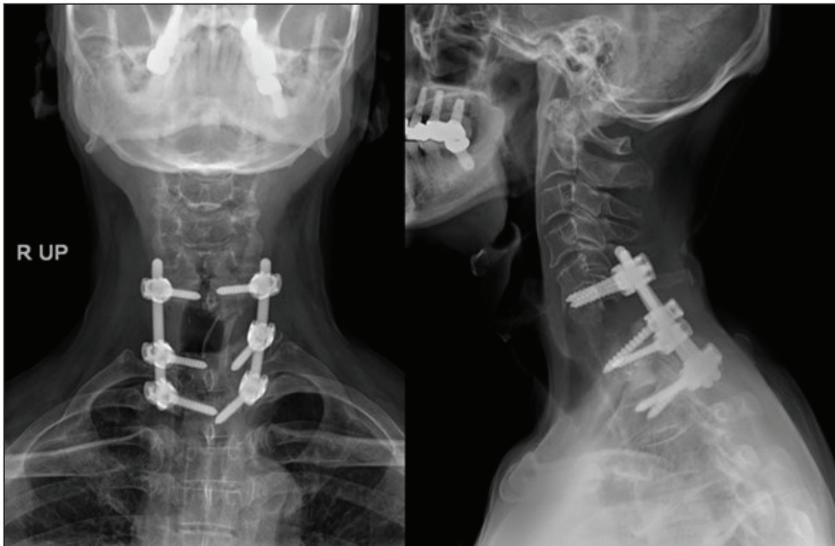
Postoperative 6 month X-ray AP/lateral view in patient 2.
